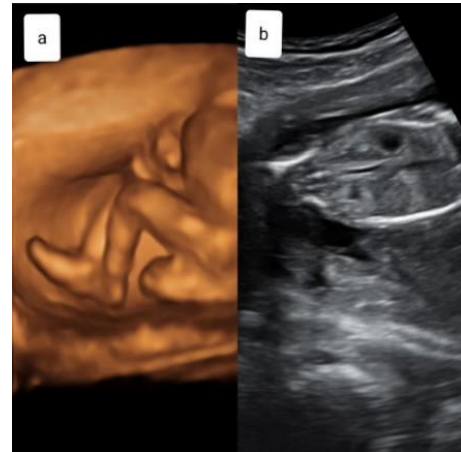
(a) parasitic lower extremity 3D ultrasonographic picture (b) parasitic lower extremity (femur) ultrasonographic picture
